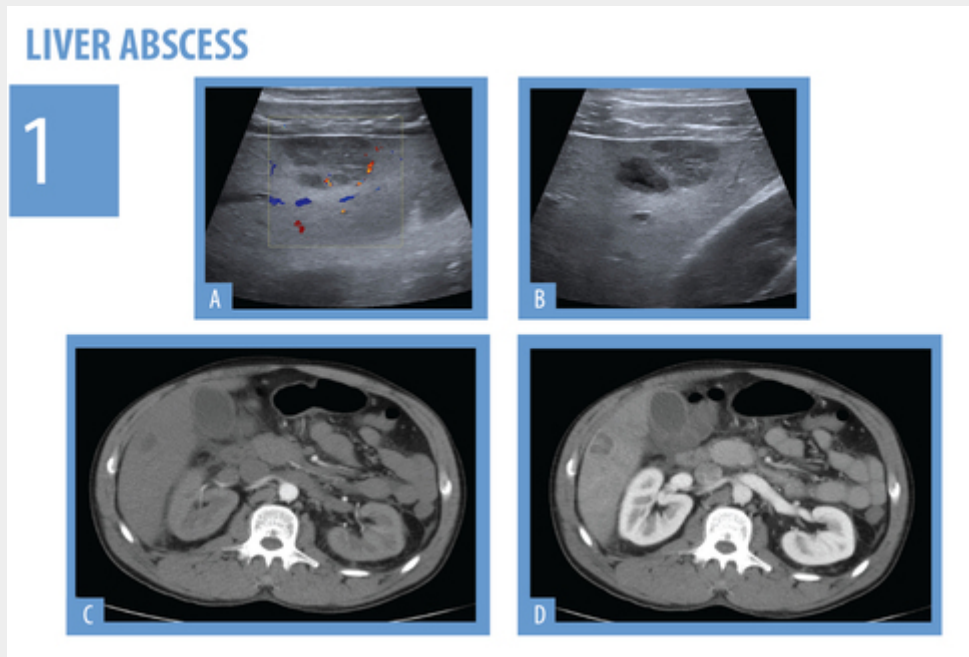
64 year-old patient presenting with high grade fever and RUQ pain. On US (A,B) there is an apparent heterogeneous image on the right liver lobe. It had no internal Doppler signal. Due to rapidly deterioration, CT (C,D) was performed before and after intravenous contrast which demonstrated a heterogeneous lesion, with irregular contours and peripheral enhancement. There seem to be some thin septa within the abscess.
